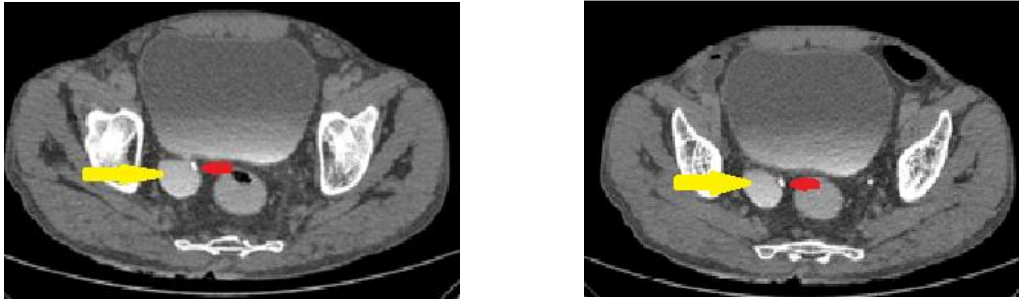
CT urography delayed axial images (a) and (b) showing a well-defined saccular outpouching (yellow arrow) arising from the right posterolateral wall of urinary bladder adjacent to the right vesico-ureteric junction. Contrast filled right ureter (red arrow) is traversing medial to the diverticulum.
